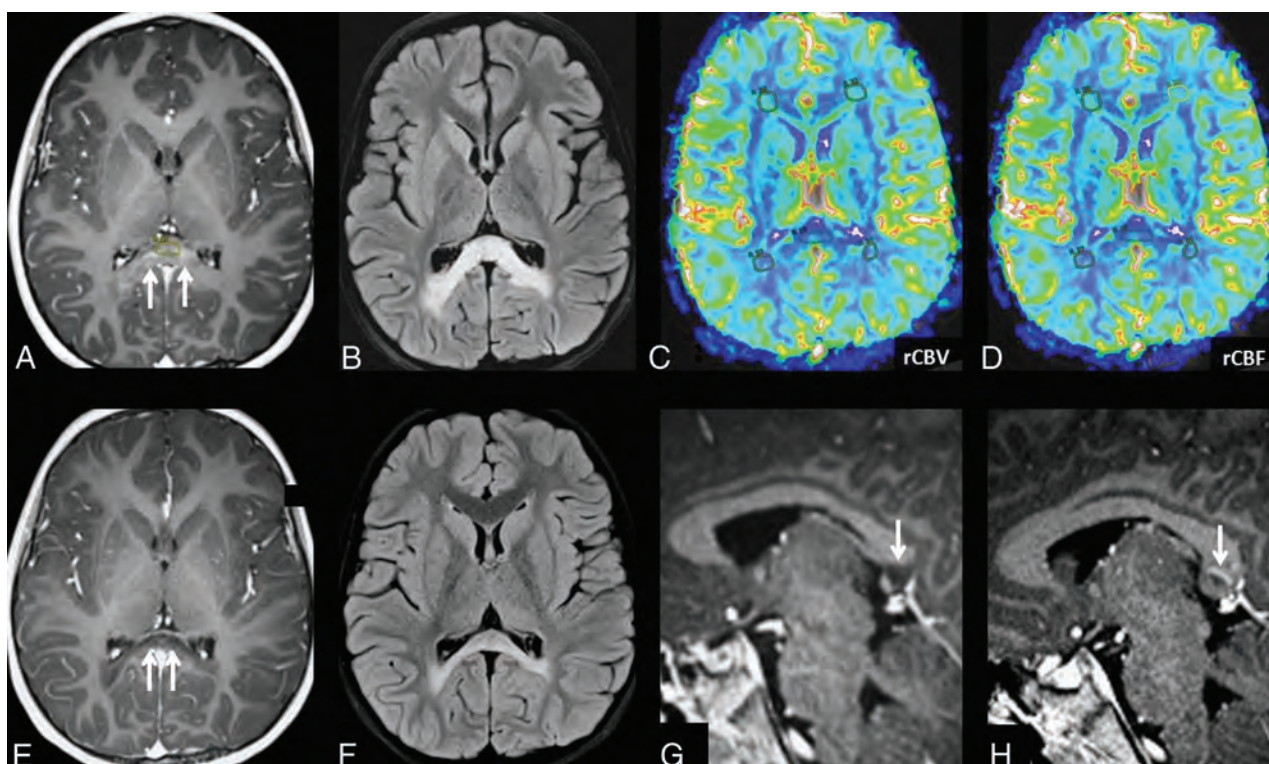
A 6-year-old boy with cALD. Pre-HSCT, a LEE (arrows) is present along the anterior SCC on postcontrast TIWI (A), with edema on FLAIR within the SCC and, to a lesser degree, within the POWM (B). Also at baseline, the CBV (C) and CBF (D) maps demonstrate ROIs obtained from the NAFWM, POWM, and SCC. After HSCT, on 1-year follow-up postcontrast TIWI (E), the LEE has disappeared, with decreased swelling and no worsening of the extent on FLAIR (F). Note that the sagittal postcontrast TIWI at 1 year (G) demonstrates the disappearance of the enhancing LEE (arrow) within the SCC, compared with the initial postcontrast image at baseline (H).
